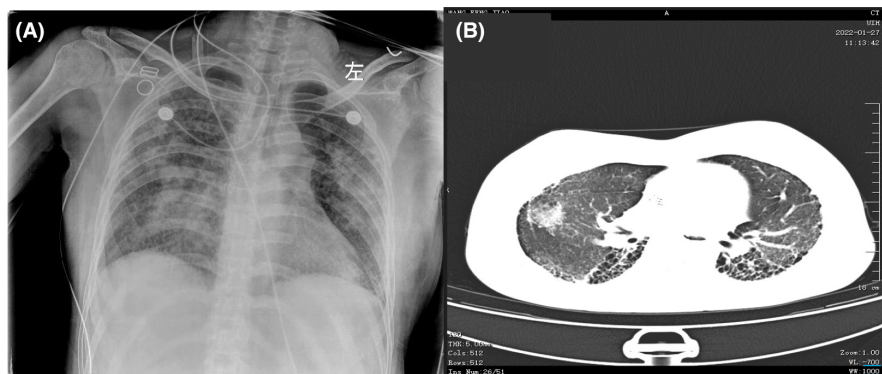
Chest X-ray (A) and computed tomography (B) examinations revealed increased infiltrations, reticular and ground-glass opacities, and multiple cord-like and patchy high-density shadows.
